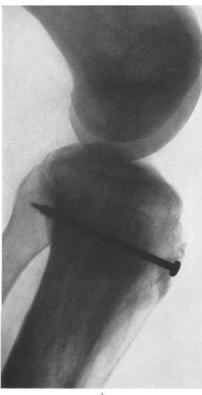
Giant cell osteodystrophy of the tibial tuberosity. Case 1. Th. Marc, aged 36 (MB. 7611/58 ZH). a X-ray from June 22, 1956: Spongiolysis in the region of the tibial tuberosity. b X-ray from April 26, 1958: Status following the traumatic avulsion and screw fixation of the tuberosity
